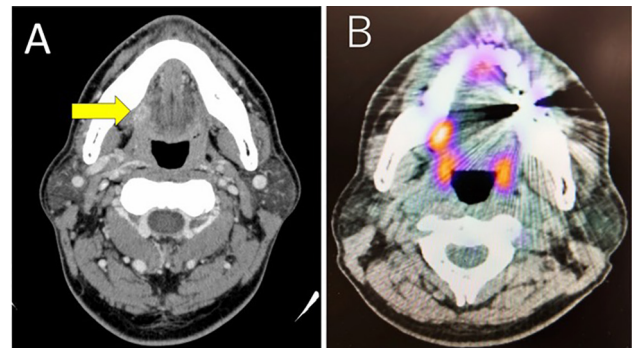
Computed tomography and fluorodeoxyglucose (FDG) positron emission tomography findings of the tongue lesion. (A) An area of strong contrast (arrow) can be seen on the right edge of the tongue. (B) An area of high FDG accumulation was observed on the right edge of the tongue.
